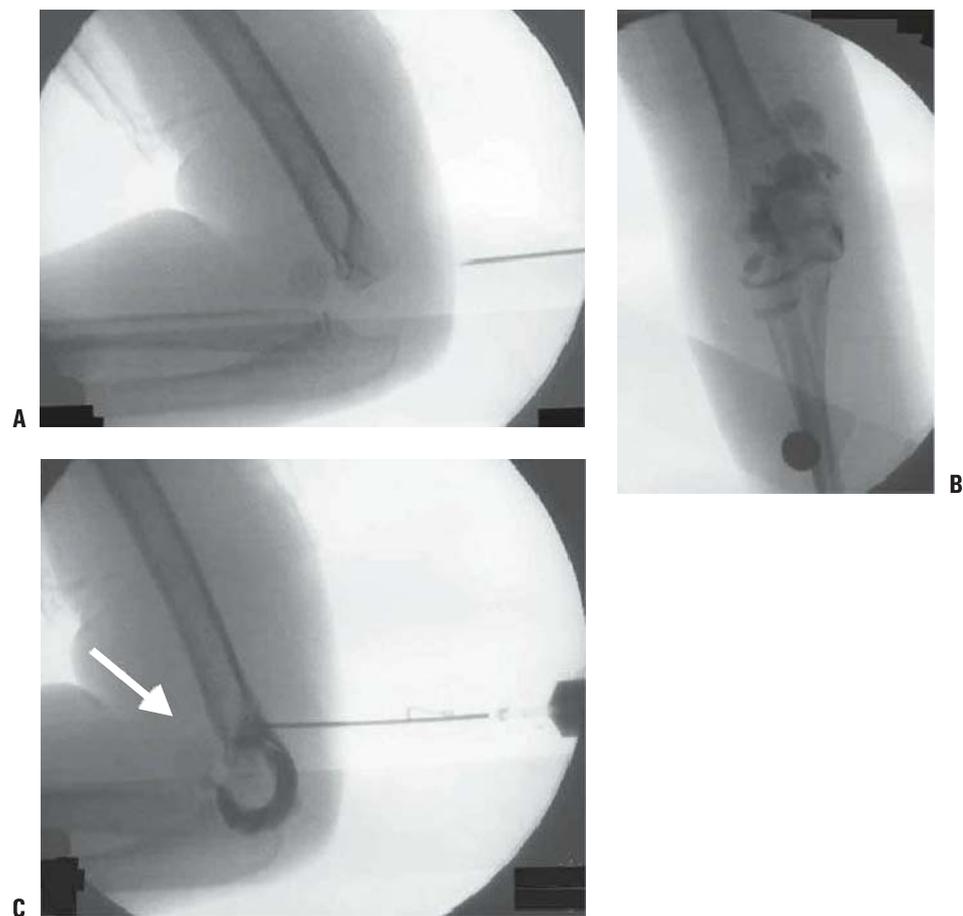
Type I fracture: <2 mm displacement, type II fracture: with ≥ 2 mm displacement and congruity of the articular surface as proved by arthrogram or MRI, and type III fracture: ≥ 2 mm of displacement and lack of articular congruity.
